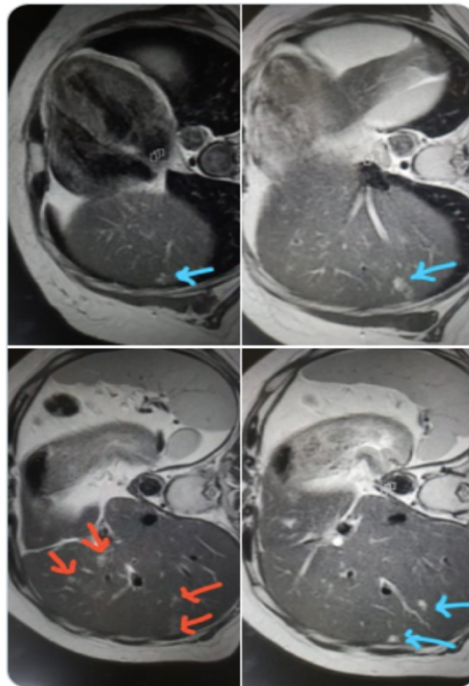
Liver MRI indicating metastatic lesions
